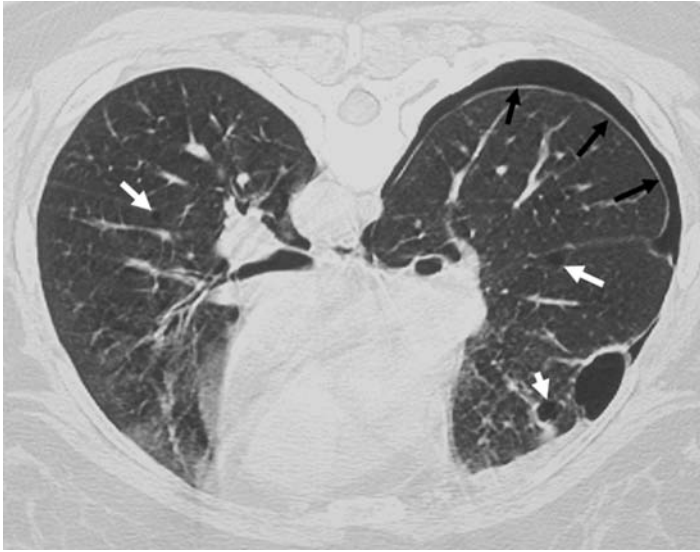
High resolution CT Chest obtained with the patient prone demonstrates pneumothorax (black arrows) and multiple pulmonary cysts (white arrows) in a patient with Birt–Hogg–Dubé syndrome.
